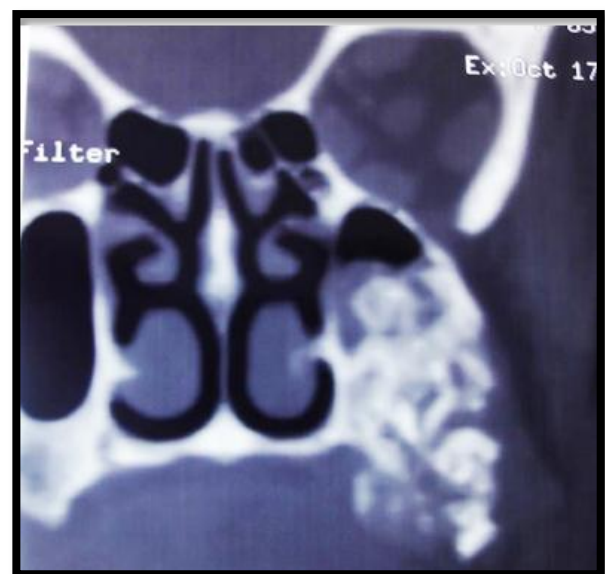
CT coronal section showing a large expansile lesion involving the left maxilla and extending up to maxillary sinus.
